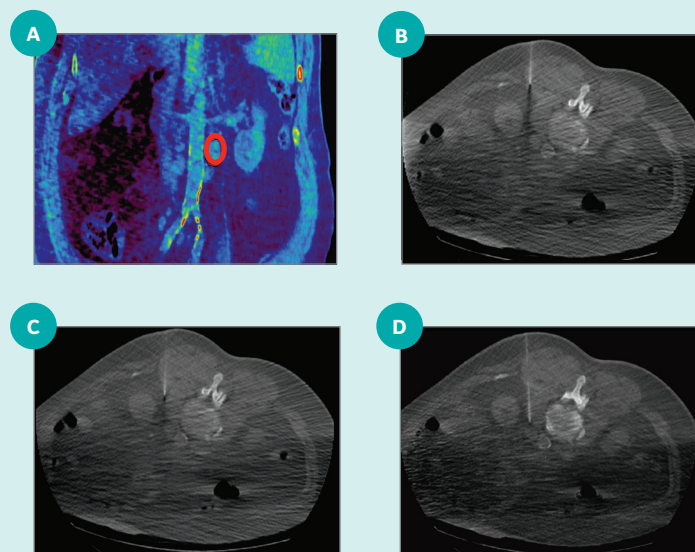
Diagnostic biopsy of a 15 cm deep lymph node metastasis that is difficult to access and is located near the aorta in an obese patient (BMI of 41 kg/m²). (A) Volume-rendered CT; (B-D) Showing three of four phases with a SmartView 3D exposure time of 7.5 sec and SmartView 3D accumulated DLP of 80.15 mGy.cm.
